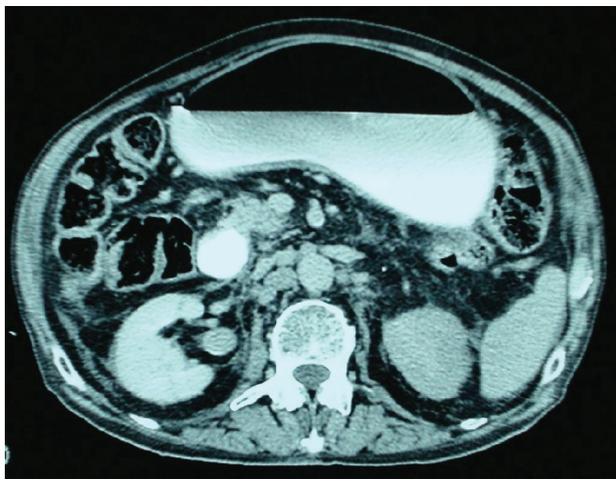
CT scan showing an infiltrative soft tissue mass in the retroperitoneum due to a metastatic transitional cell urinary bladder carcinoma, causing obstruction of the third portion of the duodenum and para-aortic lymphadenopathy
